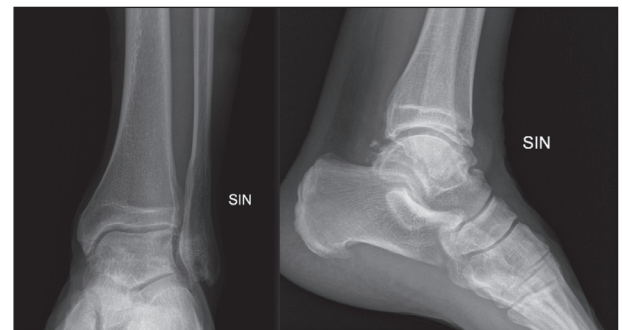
Post-operative X-ray at 10 years, shows absence of synovial chondromatosis recurrence with middle degenerative changes.
